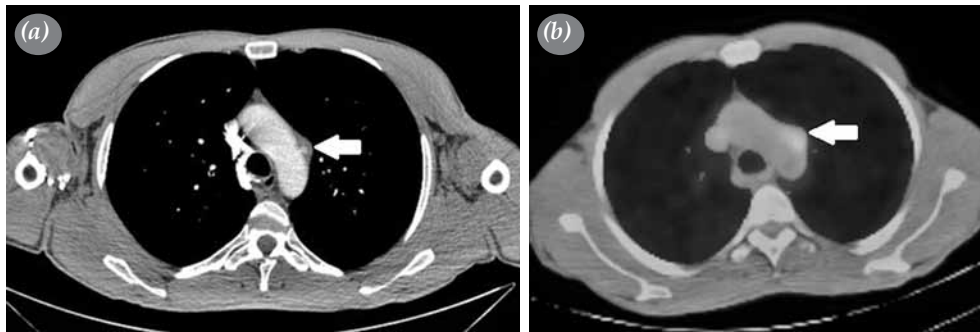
(a) Computed tomographic angiogram of the pseudoaneurysm in the aortic arch. (b) Positron emission tomography-computed tomography showing metabolic activity in the area of the pseudoaneurysm.
